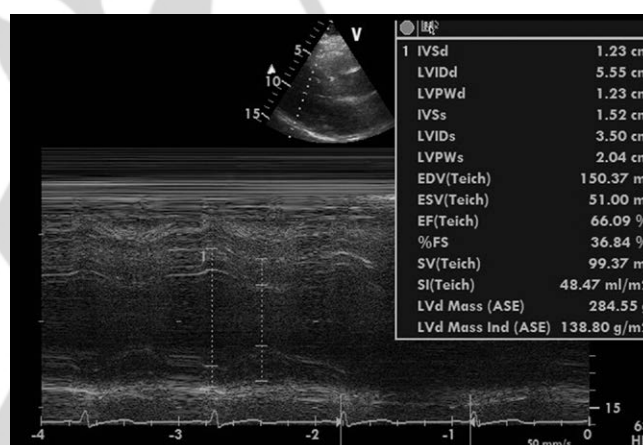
M-mode echocardiography in a male patient with primary aldosteronism – increased left ventricular posterior wall and intraventricular septum diastolic dimensions, left ventricular mass and left ventricular mass index as well as relative wall thickness (0.44) – concentric left ventricular hypertrophy. By courtesy of Dr P. Dobrowolski. ASE: American Society of Echocardiography; EDV: End-diastolic volume; ESV: End-systolic volume; EF: Ejection fraction; FS: Fractional shortening; Ind: Index; IVSd: Intraventricular septum diastolic; IVSs: Intraventricular septum systolic; LVd: Left ventricular diastolic; LVIDs: Left ventricular dimension systolic; LVIDd: Left ventricular dimension diastolic; LVPWd: Left ventricular posterior wall diastolic; LVPWs: Left ventricular posterior wall systolic; SI: Stroke index; SV: Stroke volume.
